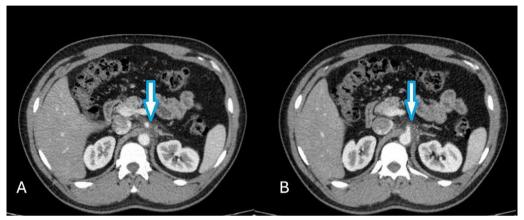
Contrast-enhanced abdominopelvic computed tomography scan in the axial plane (A, B) showing soft tissue density surrounding the origin and proximal portion of the celiac artery, resulting in minimal luminal narrowing (blue arrows). No evidence of aneurysm or dilation is observed along the course of the celiac artery
